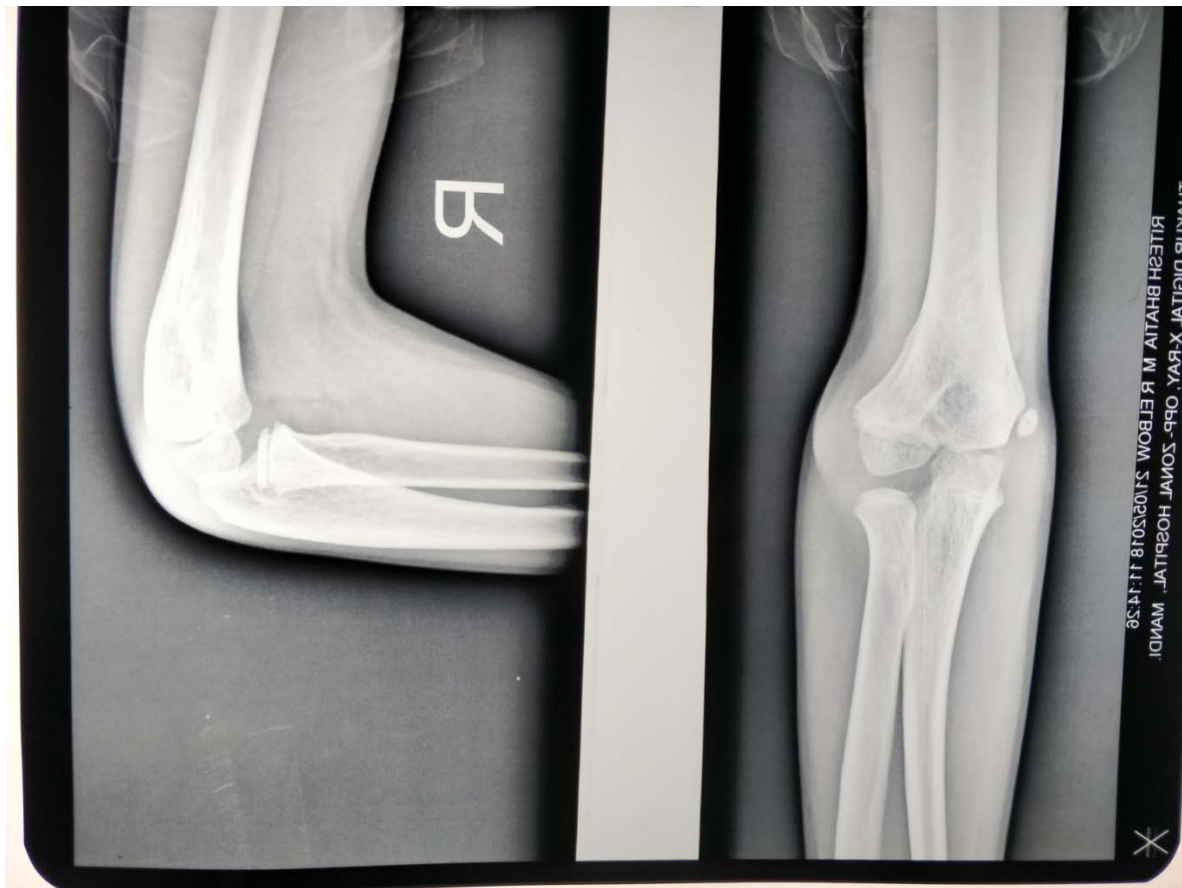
Radiographs at final follow up
